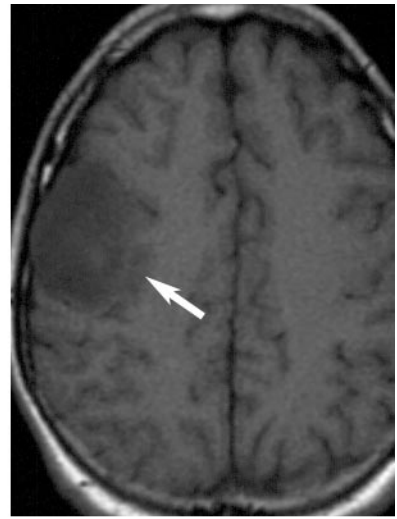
Oligoastrocytoma. (a) Axial CT image shows a hypoattenuating mass (arrow) in the left frontal lobe. (b) Axial T1-weighted MR image shows low signal intensity of the mass with mild exophytic extension beyond the normal cortical margin. (c) Axial T2-weighted MR image shows heterogeneous high signal intensity of the mass. (d) Axial contrast-enhanced MR image shows only a small focal region of enhancement (arrowhead) in the mass. (e) Intraoperative photograph shows the mass protruding beyond the normal cortical margin of the brain.
